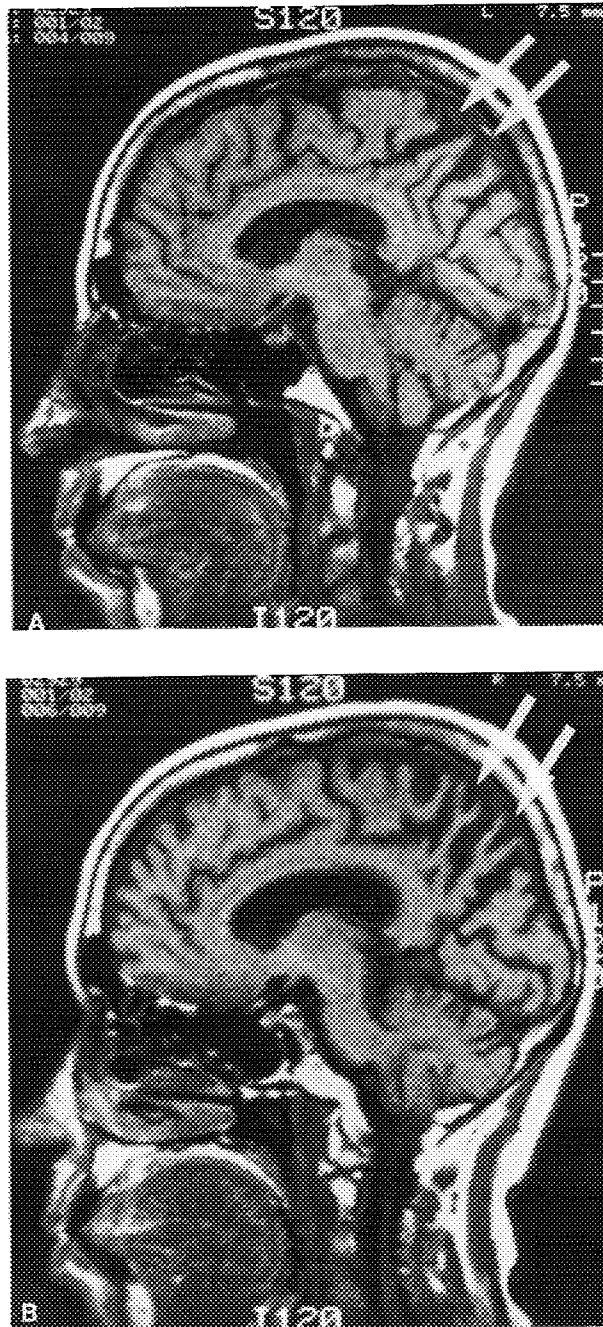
(A,B) Sagittal MRI scans taken from slightly to the left and to the right of midline showing focal parietal atrophy in the left and right hemispheres (arrows).
